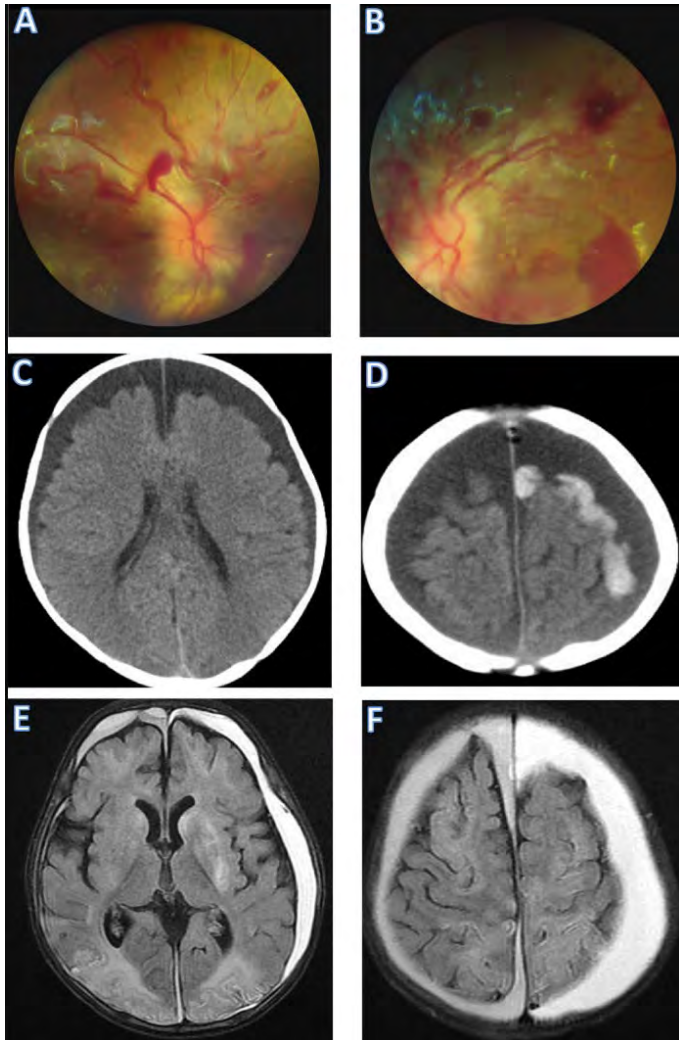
Abusive head injury in a 1-year-old female infant. (A) Right eye ground, (B) left eye ground shows diffuse intraretinal and preretinal hemorrhages. (C) Initial non-contrast CT demonstrated bilateral chronic subdural effusion, plus (D) acute left subdural hematoma. MRI (E) and (F) taken 2 weeks after bilateral subdural drainage showed asymmetric subdural fluid, as well as several parenchymal ischemic changes over frontal lobes, basal ganglia (more on left), and posterior lobes (Hung, 2020).
